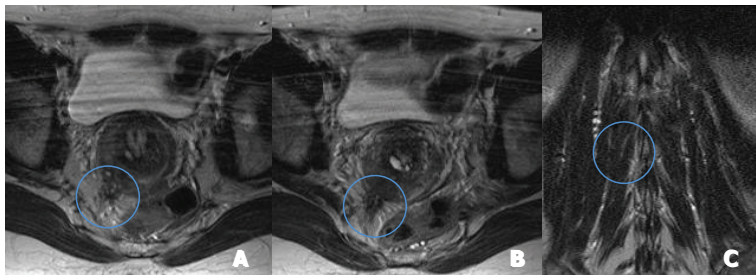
Axial (A and B) and coronal (C) T2-weighted images showing irregular thickening of the right Utero-Sacral ligaments (blue circles). On the same image there is infiltration of the rectal serosa (blue circle).
